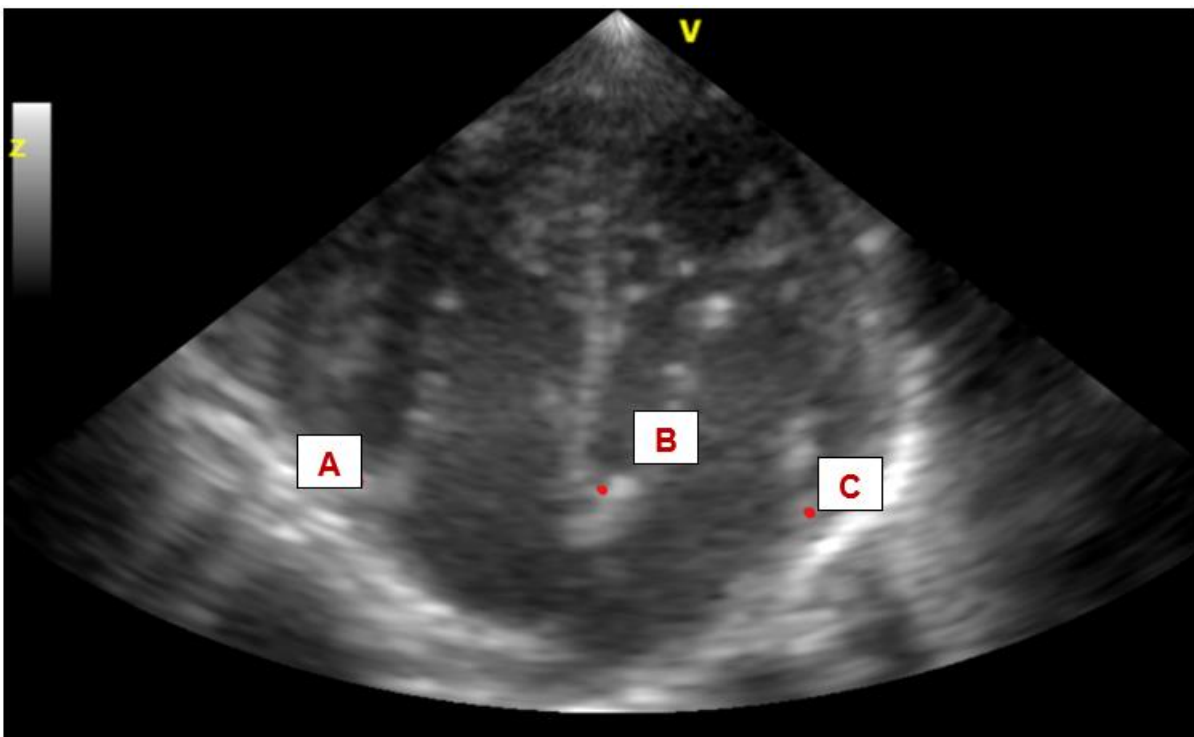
4 Apical 4-chamber view with tissue Doppler evaluation points, A: Tricuspid valve lateral annulus, B: Mitral valve Septal annulus and C: Mitral valve lateral annulus.
